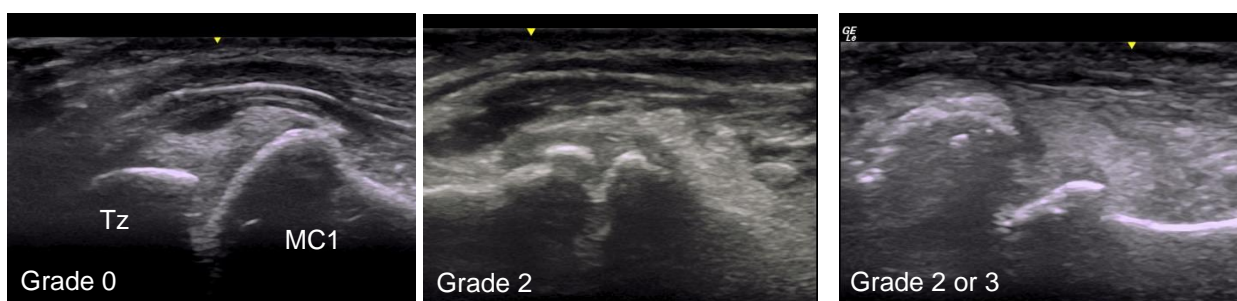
Ultrasound images of the thumb CMC joint with examples of osteophyte grade. Tz, trapezium; MC1, first metacarpal.
